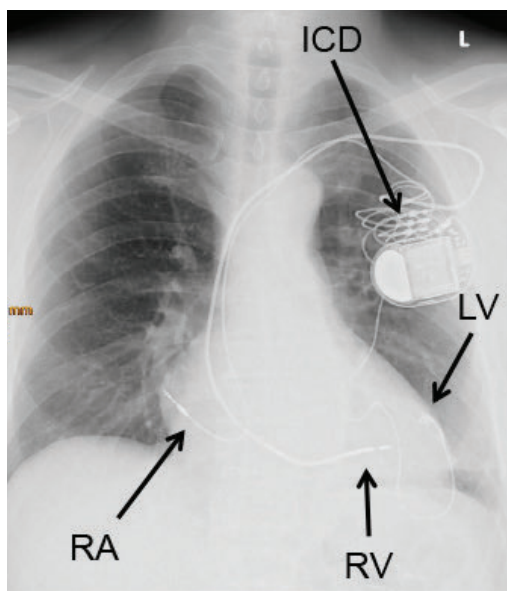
Postero-anterior chest radiography. Implantable cardioverter-defibrillator (ICD) is implanted in the upper left infraclavicular region. The atrial lead (RA) is visible in the right lateral atrial wall, and one ventricular lead (RV) is visible in the right ventricular apex. The left ventricular lead (LV) is implanted epicardially.
